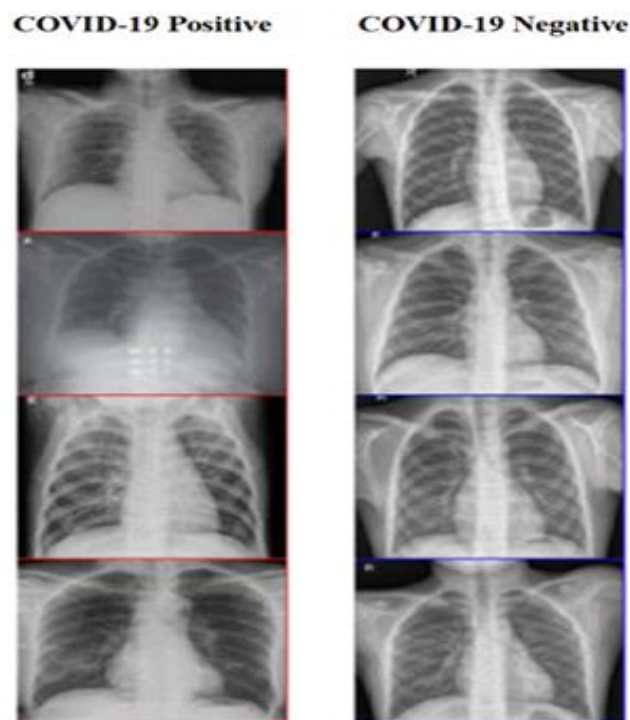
Sample Images of X-Ray Scan Dataset
